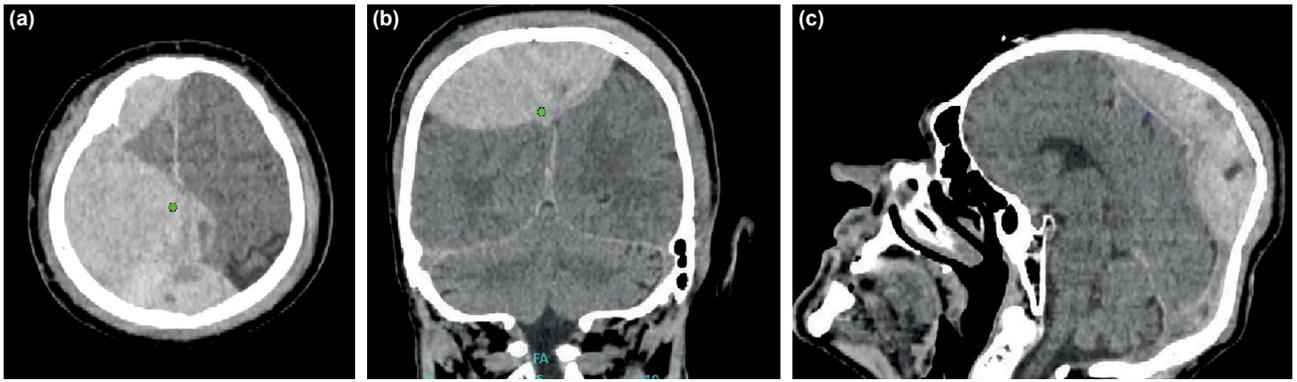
58-year-old male patient was admitted to the hospital with a Glasgow Coma Score of 15 and operated due to deterioration of consciousness and paraparesis developing during follow-up. Axial (a), coronal (b) and sagittal plan (c) computed tomography imaging of patient shows a huge epidural hematoma extending both sides of convexity with mass effect on parenchyma and depressed occipital fracture.
